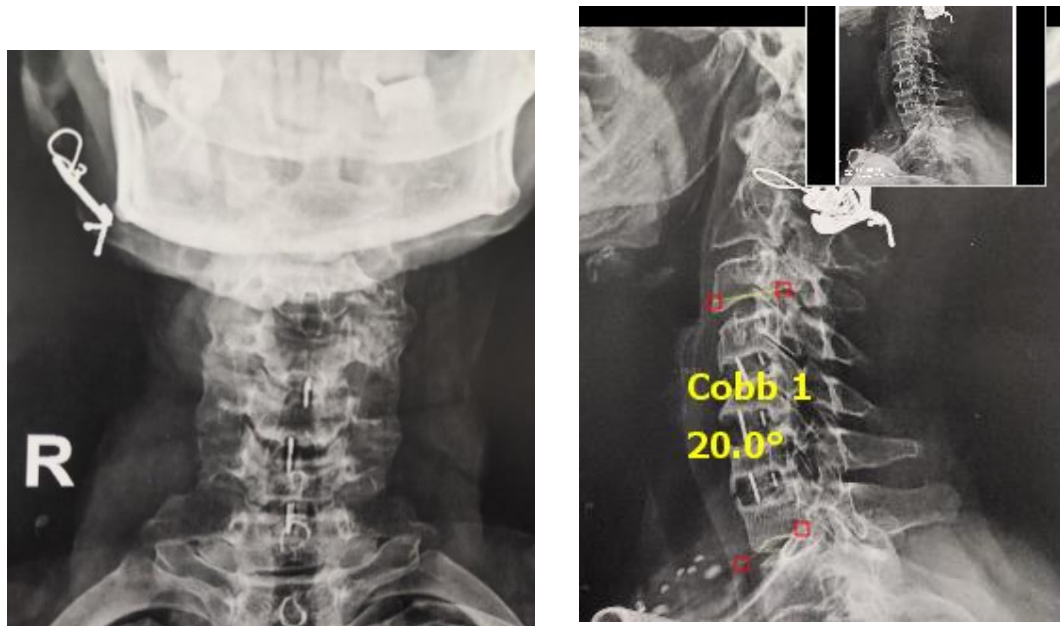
Postoperative X-ray AP and lateral view of 1 year Cobb angle 20°.
